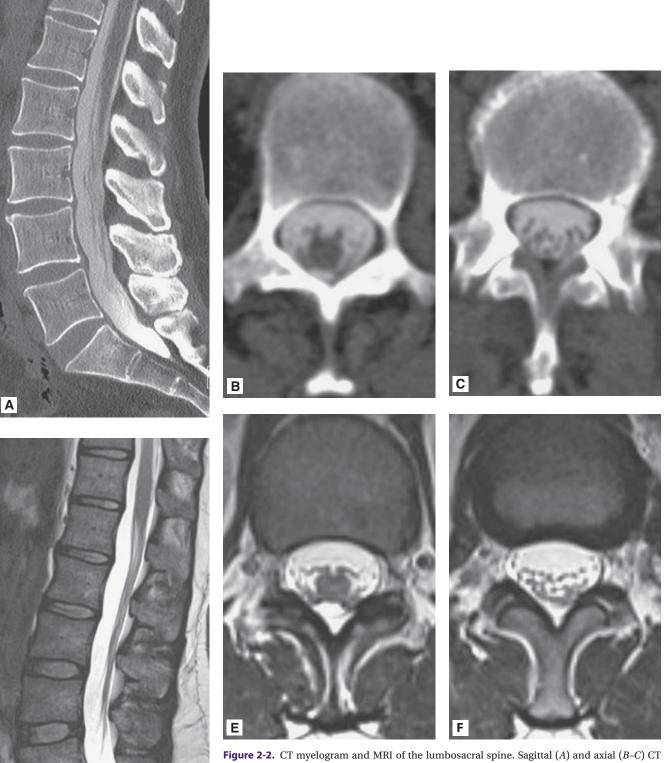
CT myelogram and MRI of the lumbosacral spine. Sagittal (A) and axial (B-C) CT images of the lumbosacral spine obtained after the intrathecal administration of radiopaque contrast material. The vertebral bodies are separated by intervertebral discs and the spinous processes are seen posteriorly. Contrast contained within the thecal sac appears white. The conus medullaris terminates at the L2 vertebral level (A-B) and the nerve roots of the cauda equina are clearly seen within the posterior thecal sac (A-C). Sagittal (D) and axial (E-F) T2-weighted MRI of the lumbosacral spine shows hyperintense CSF surrounding the conus medullaris, which terminates at the L1 vertebral level (A-B). The nerve roots of the cauda equina are seen within the posterior thecal sac (A-C). In C and F, traversing nerve roots within the lateral recess of the spinal canal are seen.
